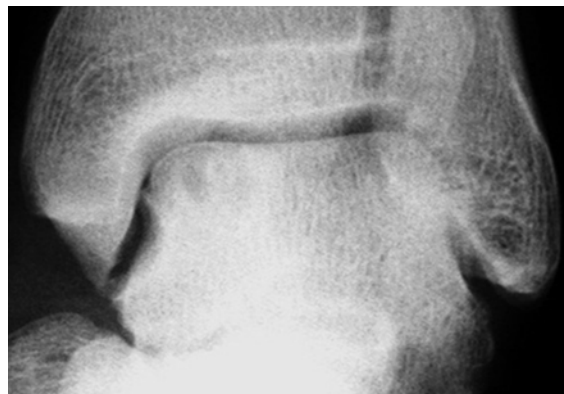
Preoperative plain radiograph of the left talus
